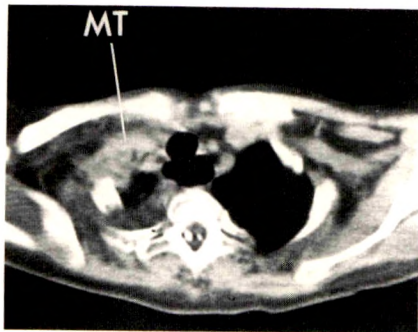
61-year-old man with Horner syndrome. CT scan shows metastasis (MT) from esophageal cancer in right subclavian triangle.
